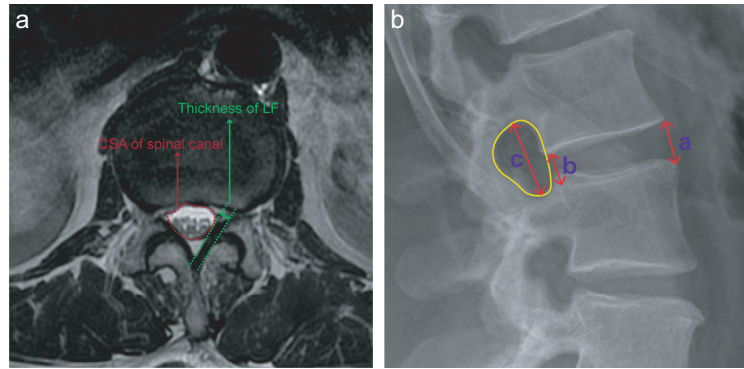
a the cross section area (CSA) of spinal canal (red dashed line and arrow) and thickness of ligamentum flavum, TL (green dashed line and arrow) were measured at the mid-disc level of the axial sequence using *T*2weighted MRI. b the intervertebral disk height (IDH) equals the average value of line a + line b, the height of the intervertebral foramen (IFH) is represented by line c, and the area within the region bounded by the yellow line is the intervertebral foramen (IFA) were measured on lateral radiography.
